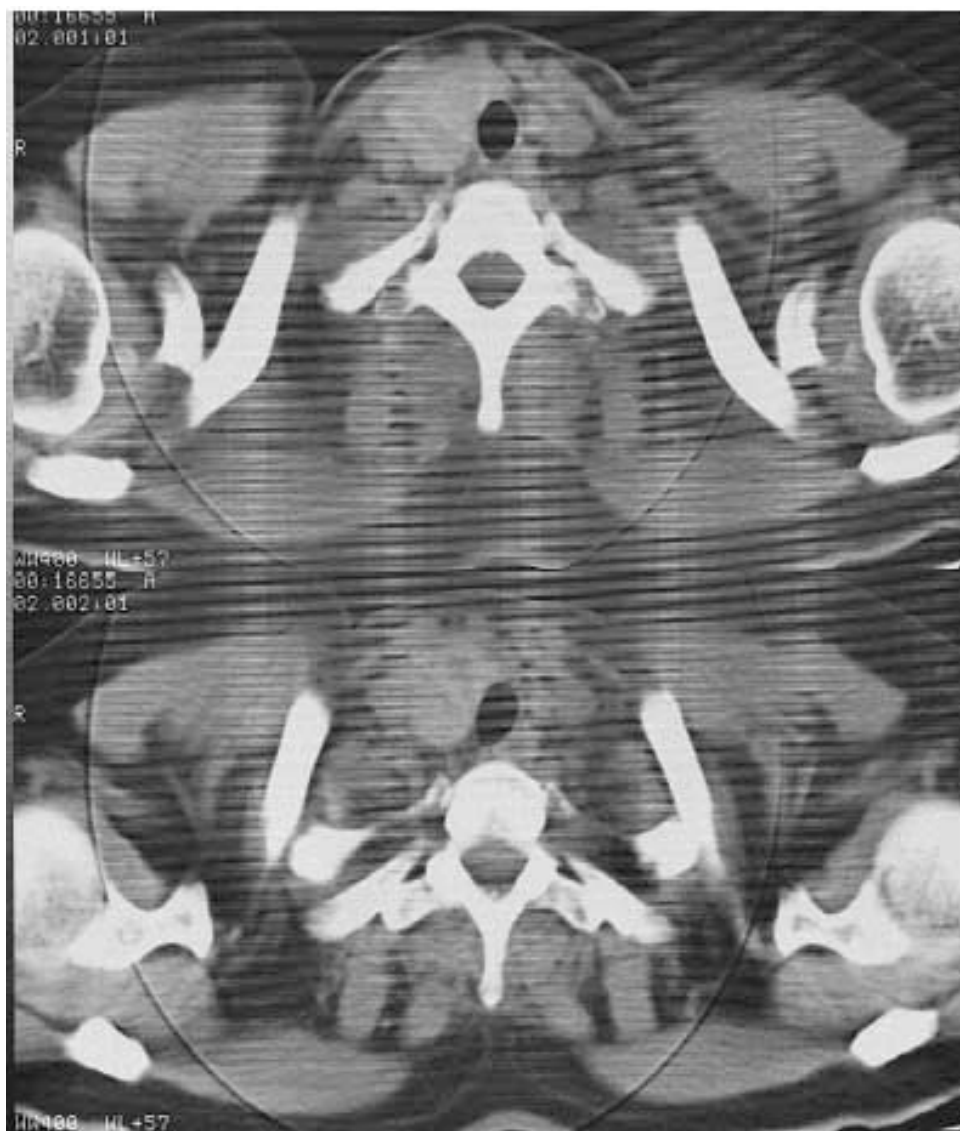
Thorax CT(case 1); showing a hyperplastic right lobe and absence of the left lobe of the thyroid gland. There were no compression signs to the trachea.
